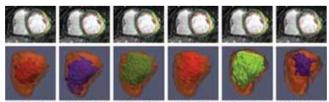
Different 3D reconstructions of infarct scar using some of the tested methods and thresholds. Top row shows the same short axis DE-MRI slice (mid-ventricular level) with manually drawn epicardial (green) and endocardial (red) contours and semi-automatic delineation of the ischemic zone (yellow). Bottom row shows the 3D bi-ventricle model (semi-transparant orange) including the 3D reconstruction of the scar from each method and threshold.
